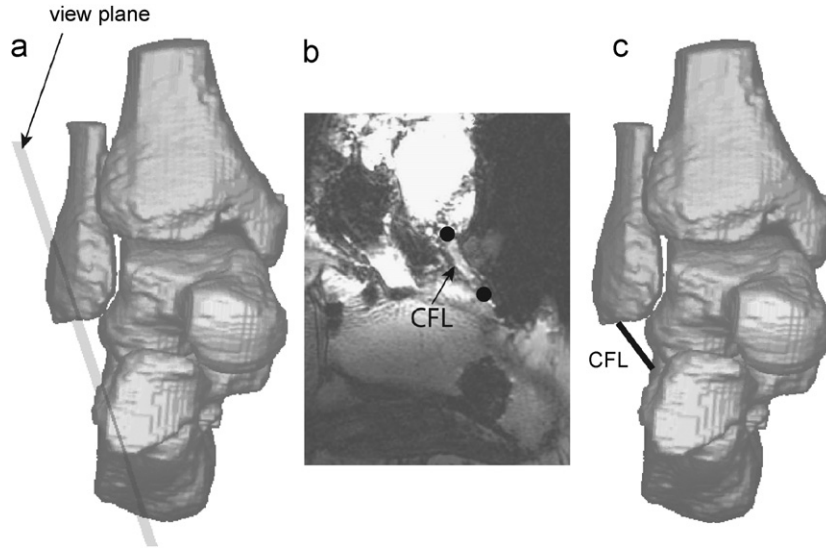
Procedure for identifying the ligaments from the MR images.
